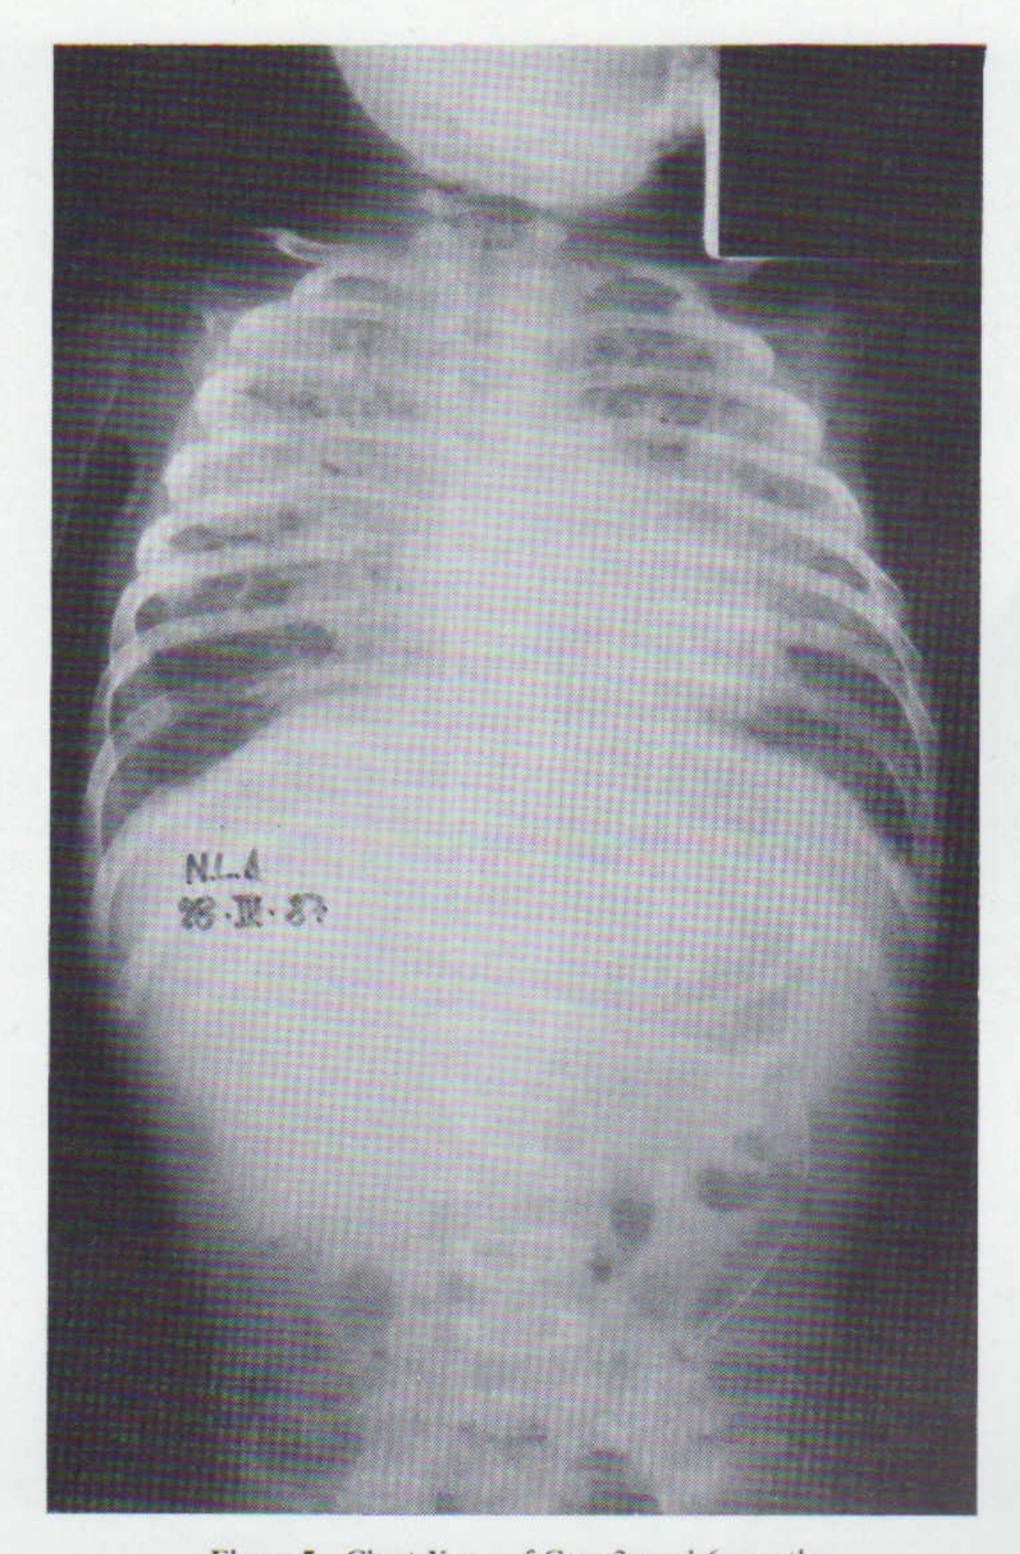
Chest X-ray of Case 2 aged 6 months.
